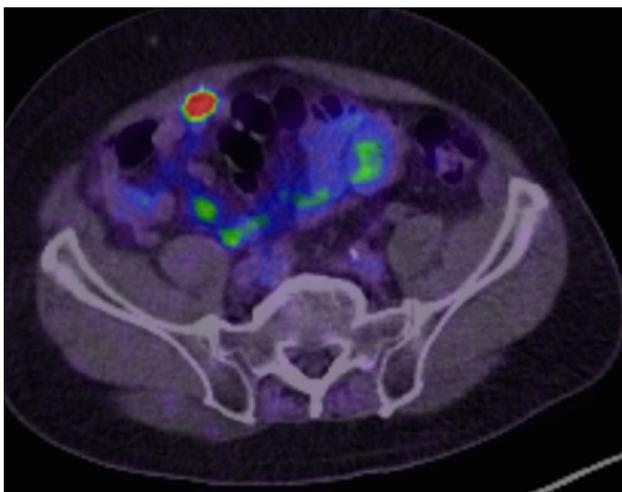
PSMA PET scan demonstrating location of lesion on the right anterior abdominal wall
